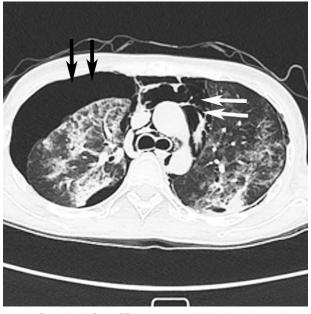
Complex ALS on CT in a 32-year-old female patient with acute lymphoblastic leukemia with a history of allo-HSCT, and with a conservative treatment duration of 26 days. PM—gas in mediastinal (white arrow), PT-gas in the right pleural cavity (black arrow). With BOOP in both lungs. Allo-HSCT= allogenic hematopoietic stem cell transplantation, ALS=air leak syndrome, BOOP=bronchiolitis obliterans organizing pneumonia, CT=computed tomography, PM=pneumomediastinum, PT= pneumothorax.
